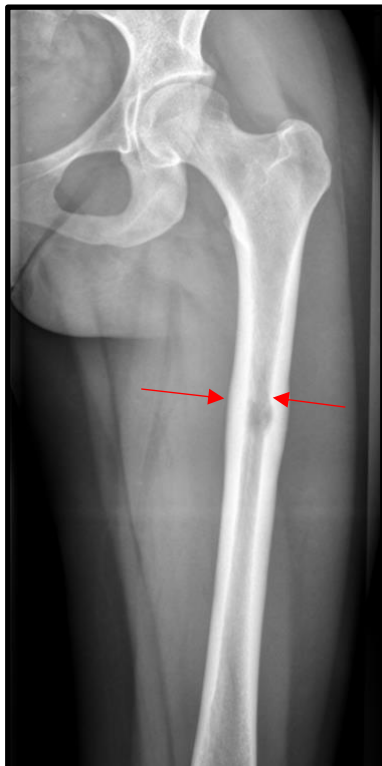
X-ray of a case of LCH in the left femoral diaphysis of a female patient at the age of 24 years. The image shows a lytic lesion that mainly involves the diaphysis or metadiaphysis of long bones. The lesion measures 2.0 cm in its proximodistal diameter and lacks a sclerotic rim. Moreover, endosteal scalloping, a periosteal reaction, and cortical thinning can be observed.
